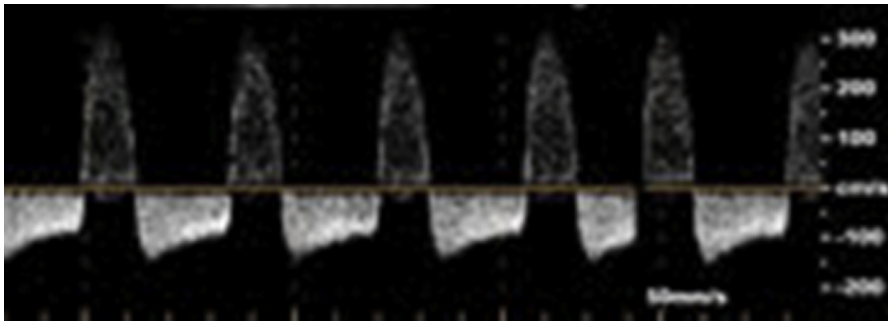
Characteristic to-and-fro Doppler waveform at the neck of the pseudoaneurysm.
